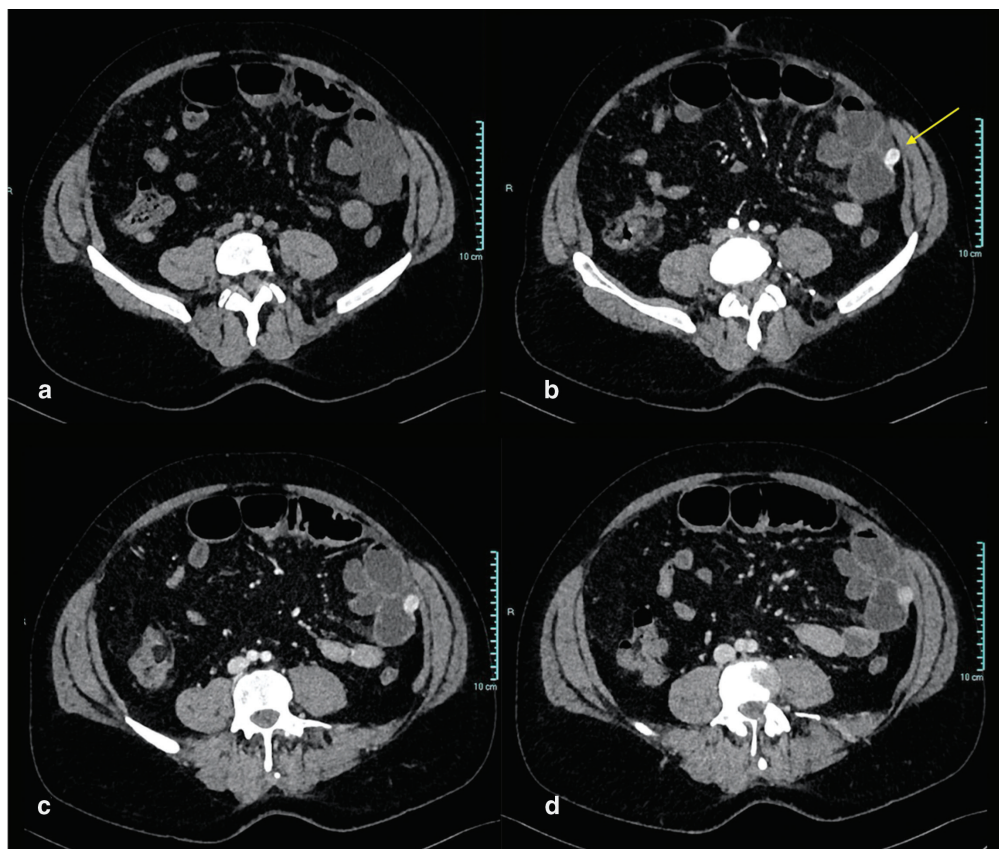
Contrast-enhanced abdominal CT scans, in the axial plane, for non-contrast (a), arterial (b), venous (c), and delayed (d) phases. The CT scans showed a 15 mm solid lesion in the wall of a jejunal loop (arrow) with exophytic growth, intense enhancement in the arterial phase (b), and wash-out in the subsequent phases (c,d), indicative of GIST.
